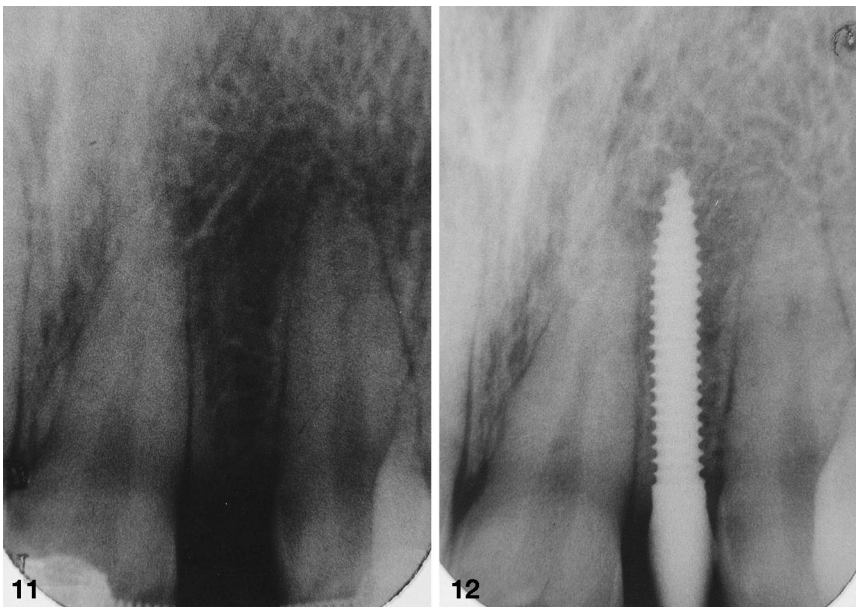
Preoperative apical radiograph.
